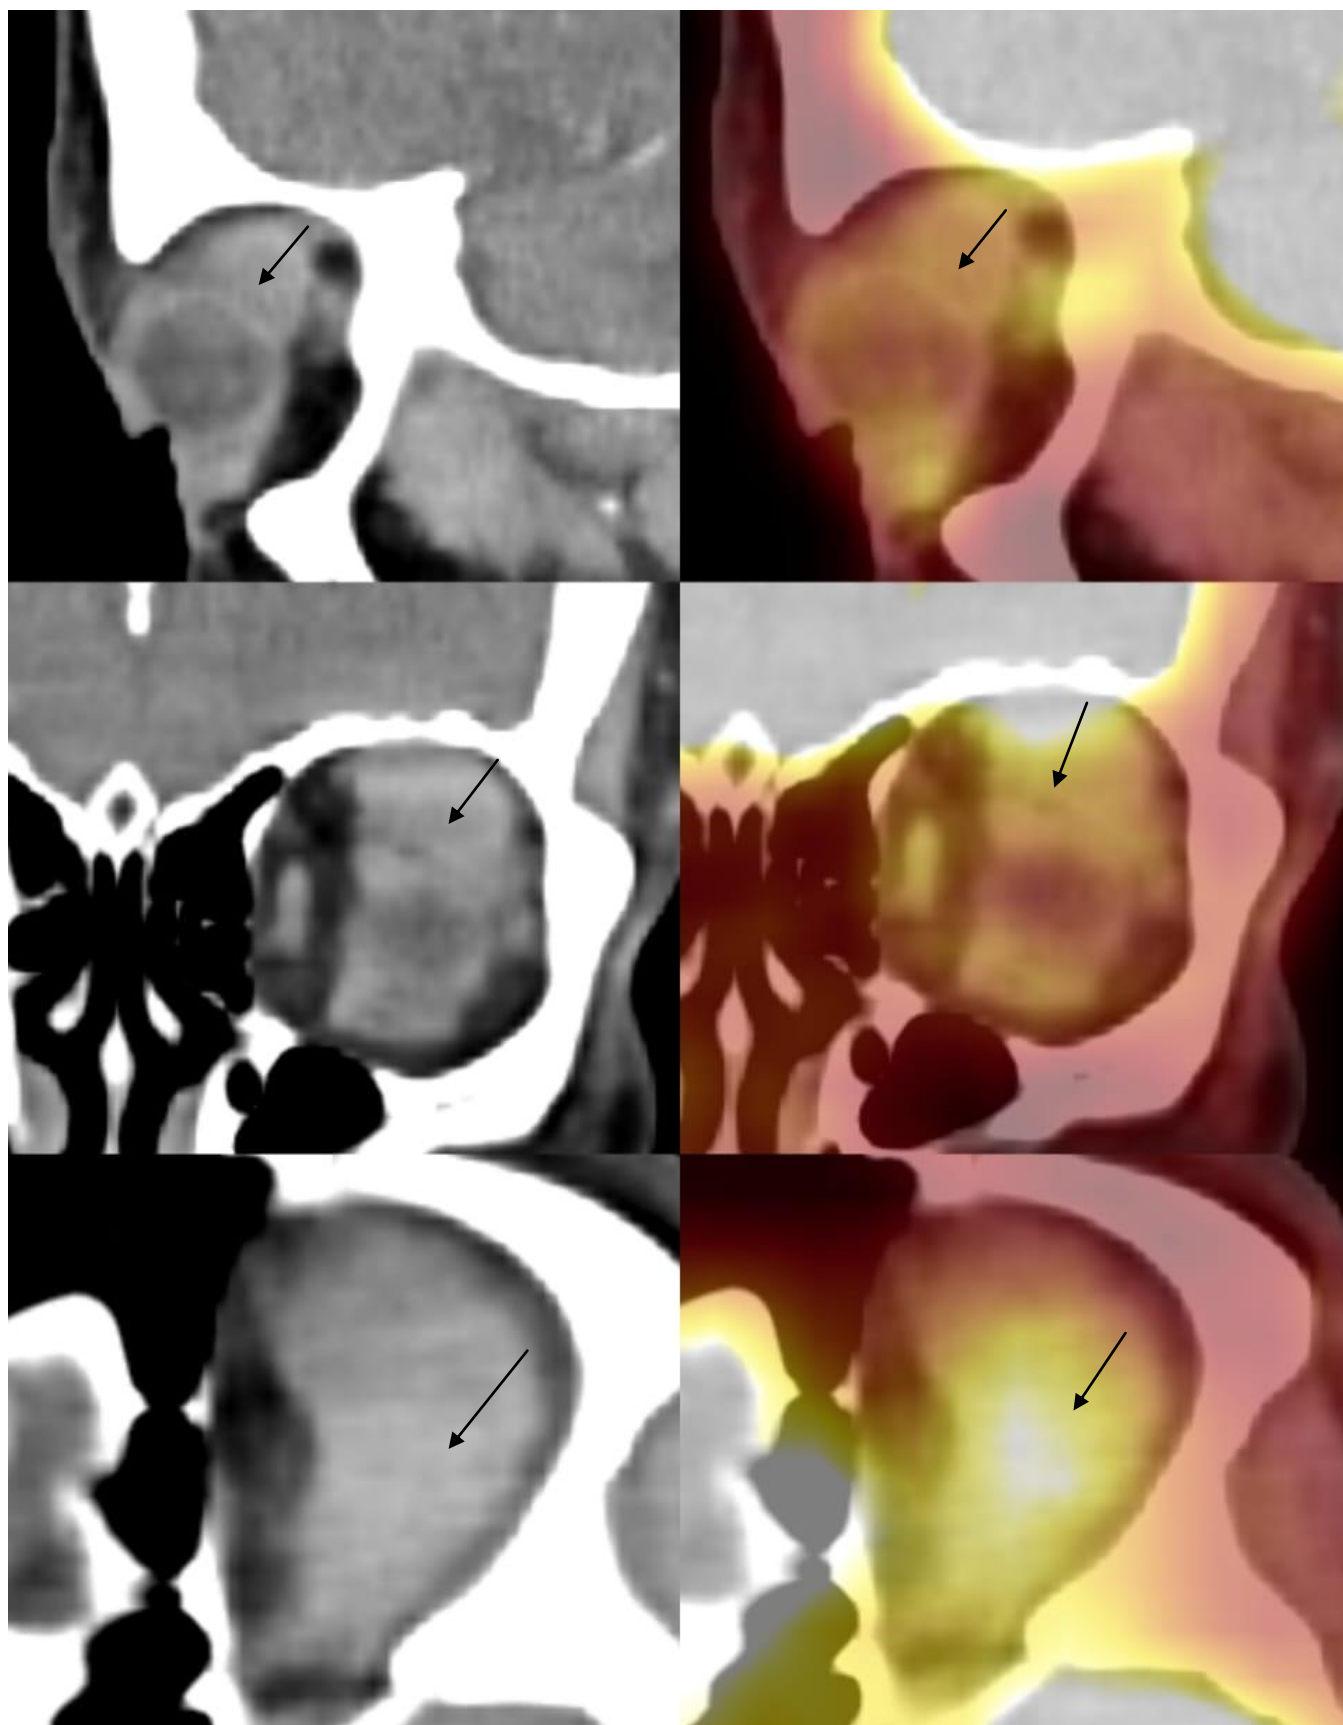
Multiple axials, coronal and sagittal CT and PET- CT images of patient show a hypermetabolic, almost homogeneously enhancing, extraconal mass lesion (shown by arrow mark) at supero-lateral aspect of left orbit.
